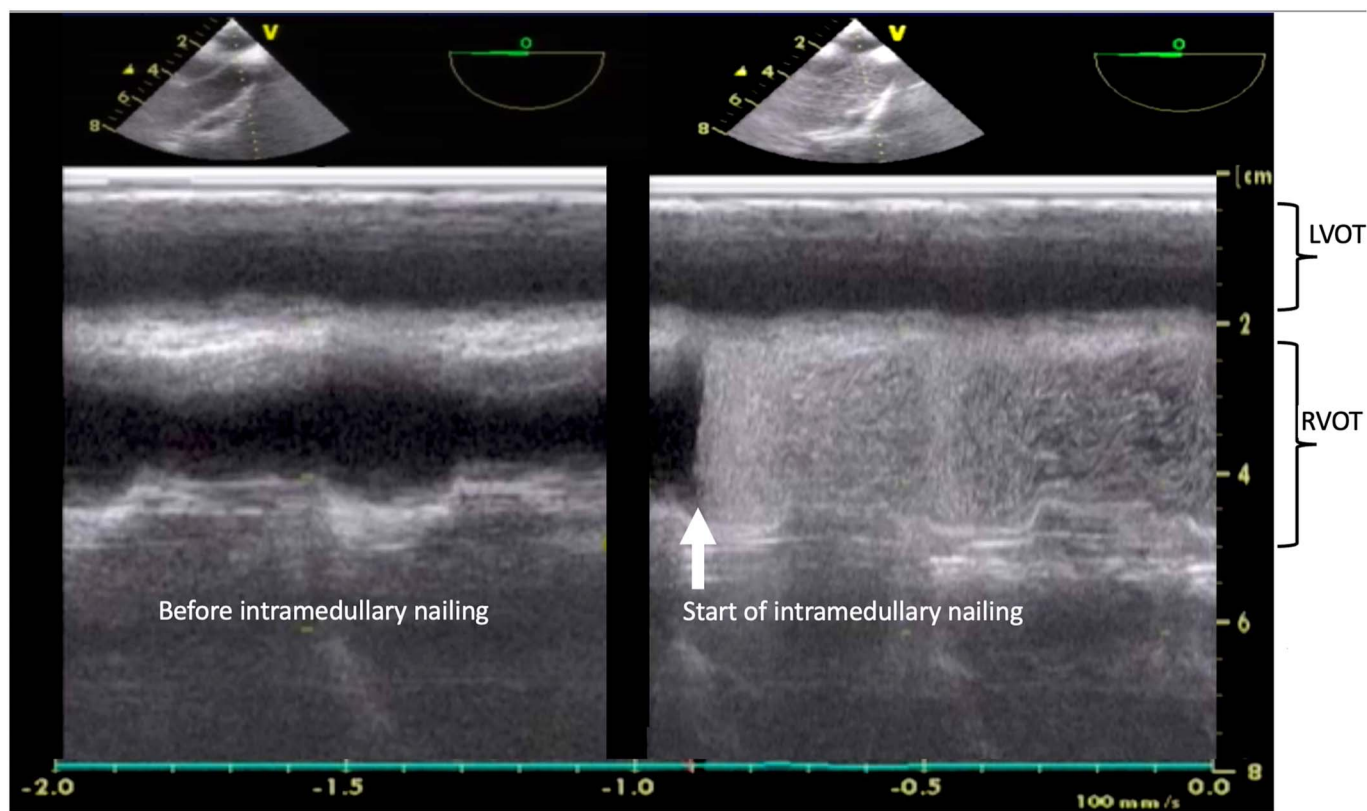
Transesophageal echocardiography with an M-mode image showing the left and right ventricular outlet tracts (LVOT and RVOT, respectively) before (left image) and immediately after (right image) femoral intramedullary nailing. The x axis shows time in seconds, and the y axis shows depth in centimeters. Dense, hyperechogenic material filled the RVOT as intramedullary nailing commenced. No emboli were visible in the LVOT.
